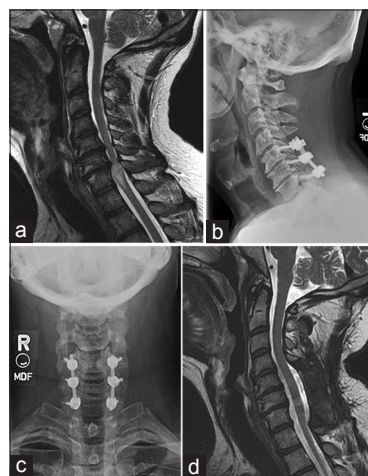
(a) T2-weighted sagittal MRI of a 47-year-old male with a history of CSM and severe gait dysfunction. He has spinal cord compression and significant spinal cord edema at the C6-7 level. He underwent C5-7 laminectomy and fusion to treat his condition. Postoperative lateral (b) and AP (c) plain radiographs demonstrate satisfactory placement of hardware and maintenance of his spinal alignment. He achieved significant gait improvement after surgery, and postoperative MRI demonstrated excellent spinal cord decompression and resolution of the edema
